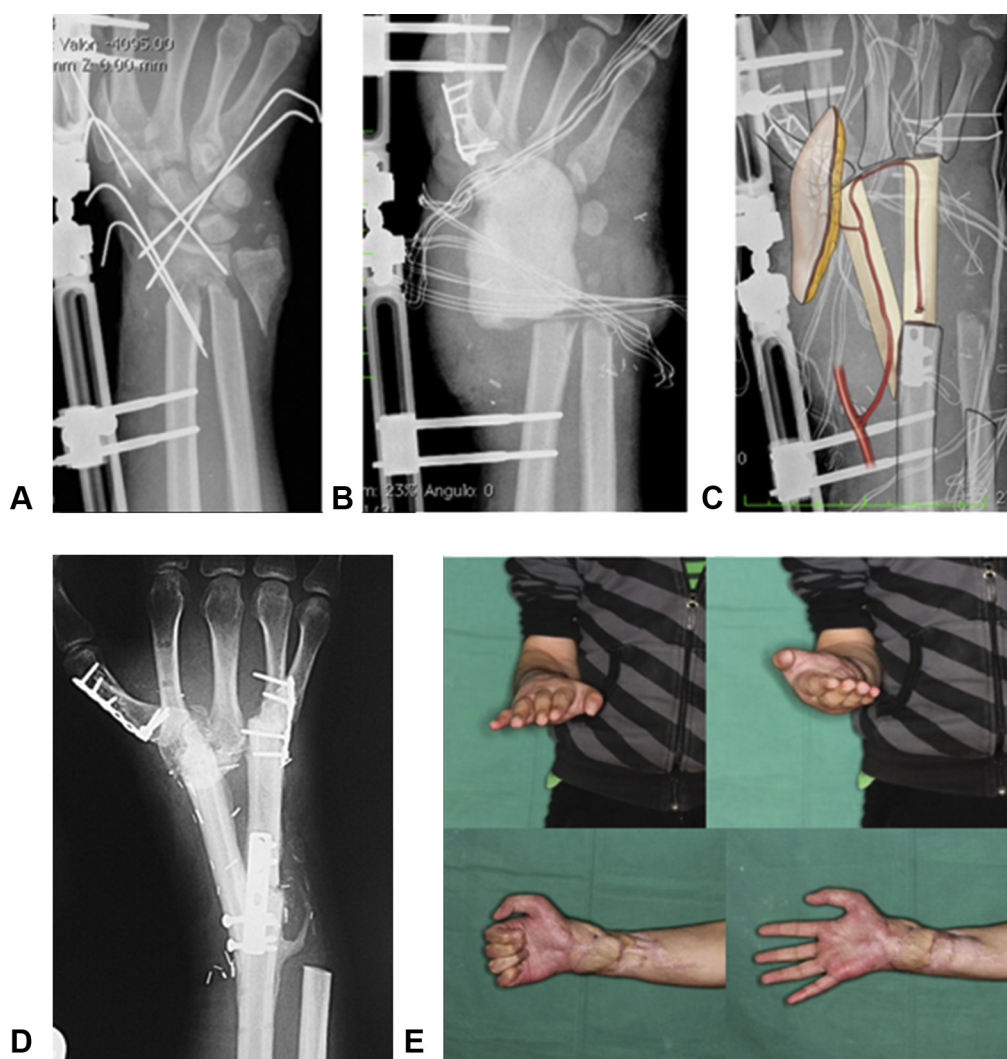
A Preoperative radiographs, with the infected bone exposed because of associated soft tissue loss. B The antibiotic spacer was left for a week, followed by insertion of TVFFF. C Artistic rendering of the reconstruction. D Radiograph 1 year after surgery. E Clinical photographs 1 year after surgery.
